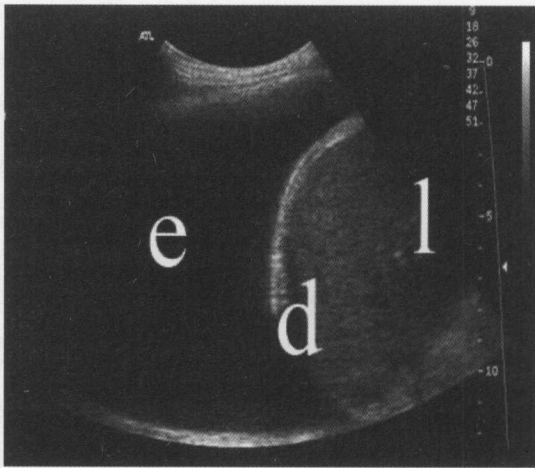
Ultrasound image of a large right sided effusion. The top of the image represents the probe resting on the chest wall, the dark area (e) is the effusion which has completely displaced the lung. The bright band (d) is the diaphragm, with the liver (l) inferior (to the right)
